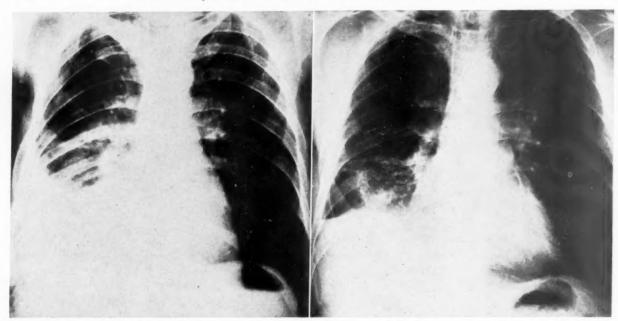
Middle-aged white man with multiple draining sinuses over the anterior chest. A. bovis had been recovered from purulent drainage, but previous intermittent treatment with penicillin and sulfadiazine had been inadequate. Chest roentgenogram (left) revealed a right empyema. Six months after the institution of intensive penicillin therapy all sinuses had healed and there was extensive clearing on chest roentgenogram (right).
